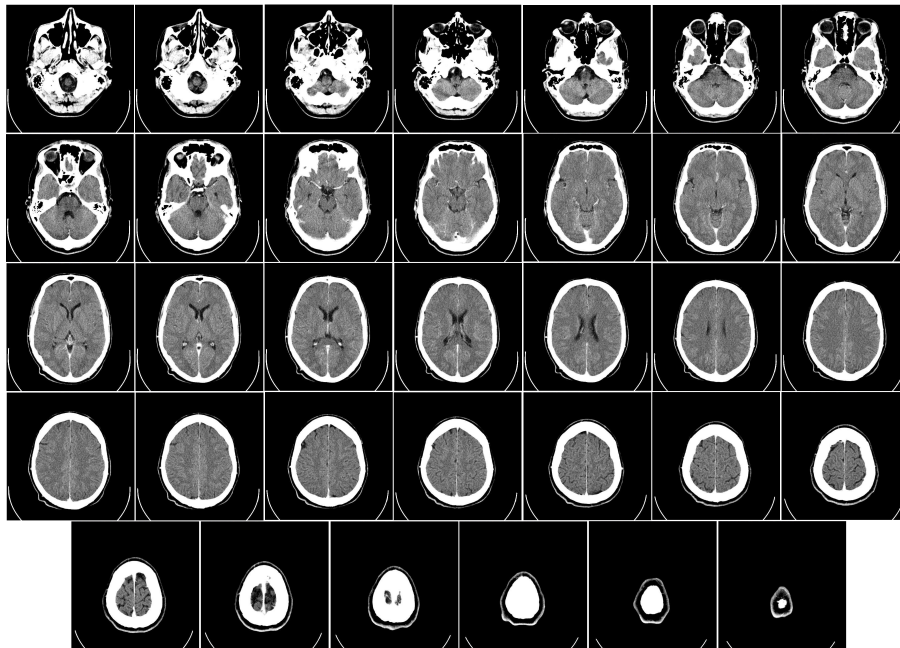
Computed tomography scan of the brain, axial view.
